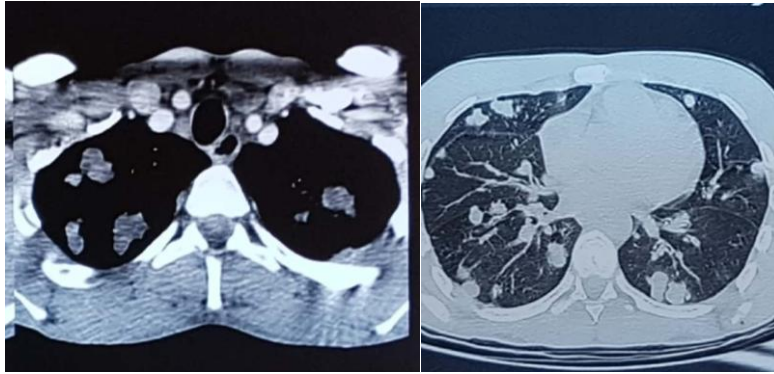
Chest CT scan. Multiple bilateral cystic formations
